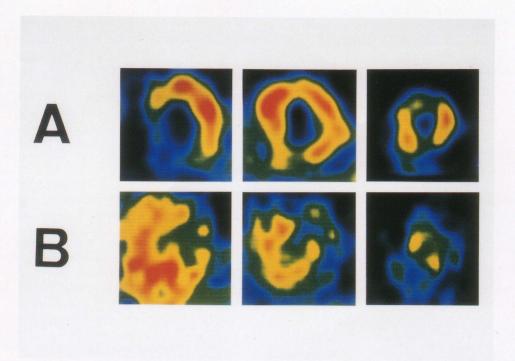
Short axis image of thallium-201 (201Tl) myocardial SPECT on admission showed a defect in septal and posterior wall regions (A) and a accumulation of technetium-99m hydroxymethylene diphosphonate (99mTc-HMDP) was observed (B) in these regions where 201Tl defect existed.
